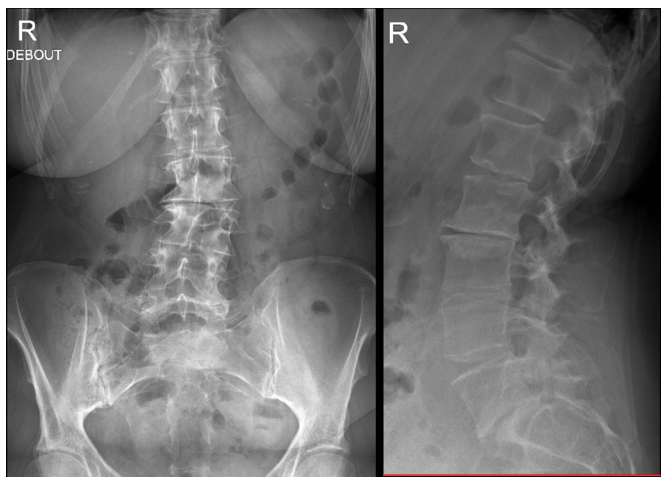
X-ray of the lumbosacral.
